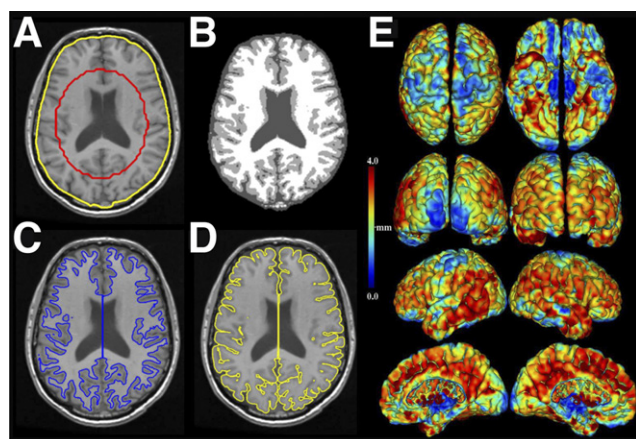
Steps in the cortical thickness analysis with extraction of the cortical boundaries. (A) Spatially aligned MRI data with initiating extraction contours superimposed. (B) Brain tissue classified as white and gray matter and cerebrospinal fluid. (C) White and (D) gray matter surfaces superimposed on MRI data. (E) The cortical thickness distribution of a healthy subject is shown.
